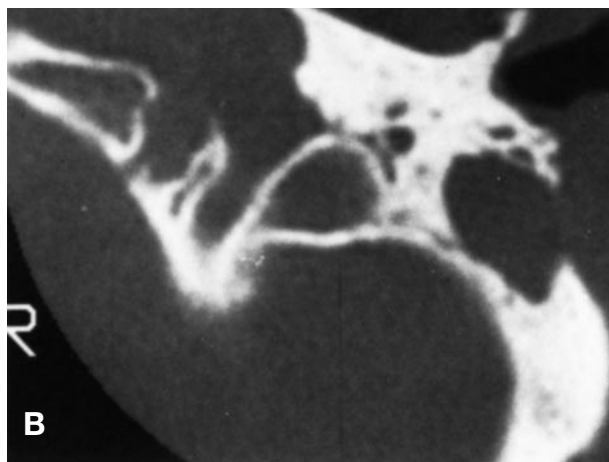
Low tegmen. Coronal computed tomographic section. The low-lying dura covers the roof of the external auditory canal and the middle cranial fossa deepens to form a groove lateral to the attic.
